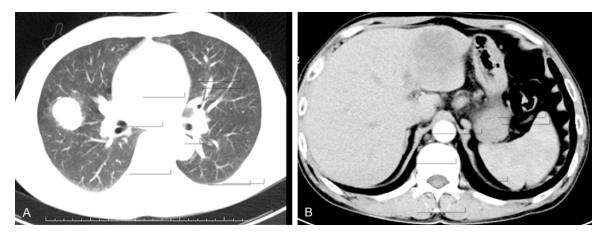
Chest and abdominal Contrast-enhanceed computed tomography of the patient. A. Chest CT showed an ovoid lesion in the middle lobe of the right lung. B. Abdominal CT showed a hypodense hepatic lession with irregular margins in the left lobe of the liver, and showed peripheral rim enhancement in the arterial phase.
